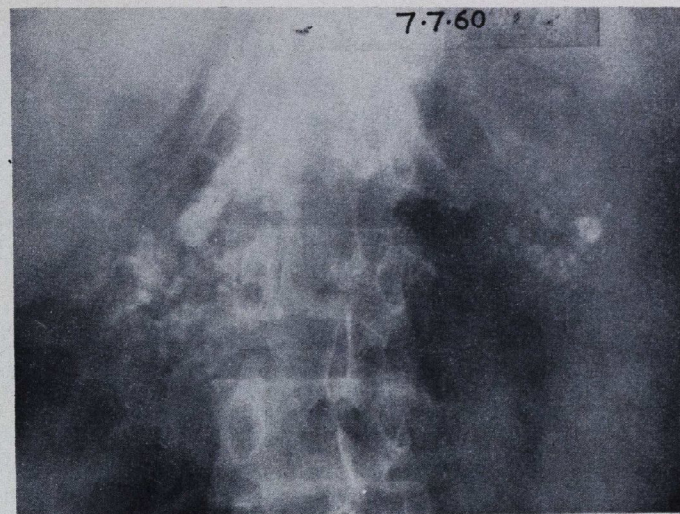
Plain X-ray of abdomen.
